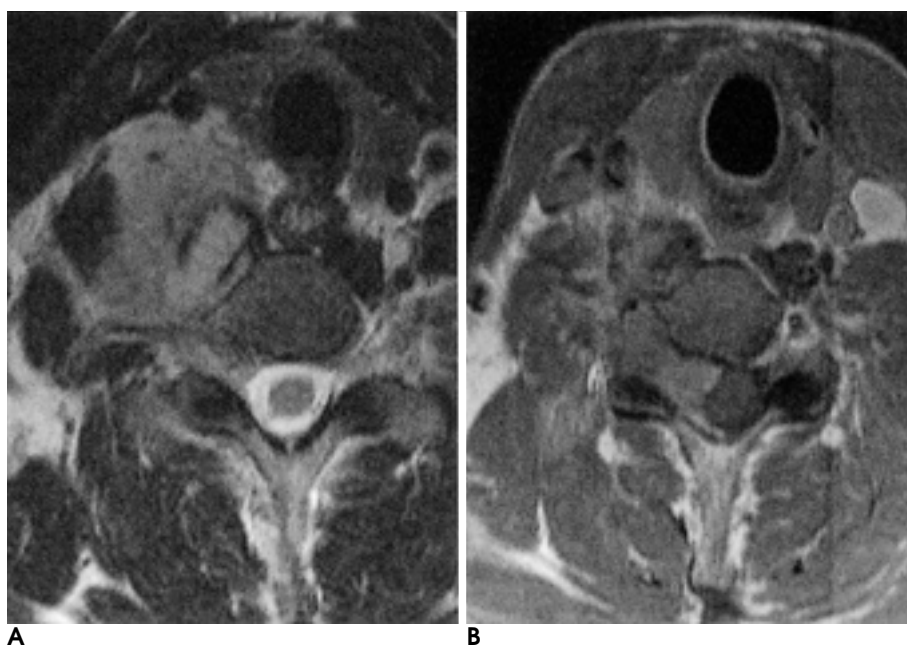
A 39-year-old man with extraskelatal Ewing's sarcoma. Axial T2-weighted (A) image shows epidural and paraspinal mass. The mass enhances on contrast enhanced T1-weighted (B) image, encasing vertebral artery.
